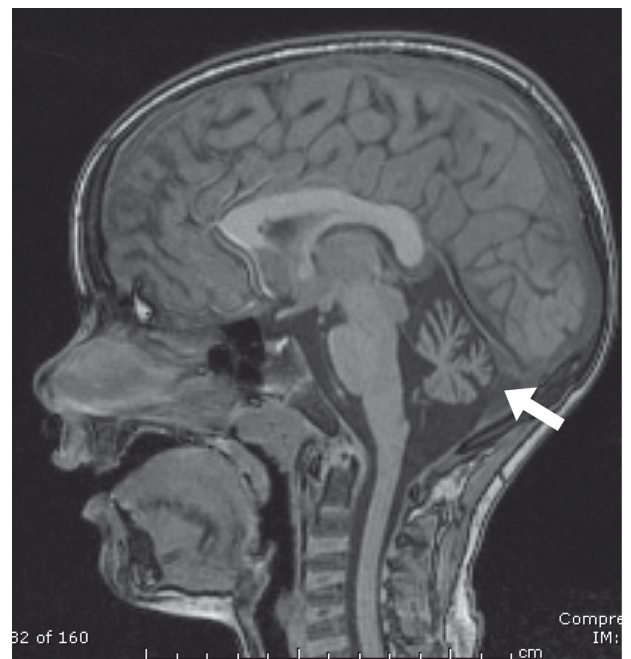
Brain MRI of proband CMH000001. An MRI taken at 8 years of age in patient CMH000001 demonstrated marked cerebellar atrophy, as denoted by the arrow.
